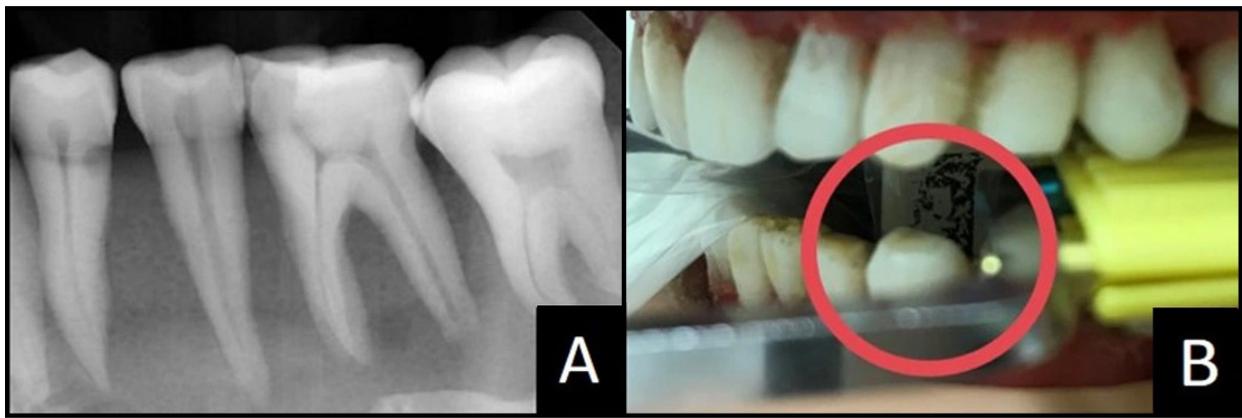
Premolar Periapical
